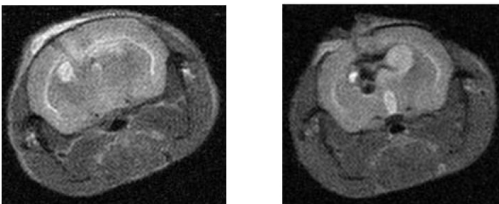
Left: T2-weighted MRI showing a tumor xenograft with bright signal (hyperintense-white area). Right: MRI signal drop (hypointense-black area) after CED of Cetuximab-IONPs
